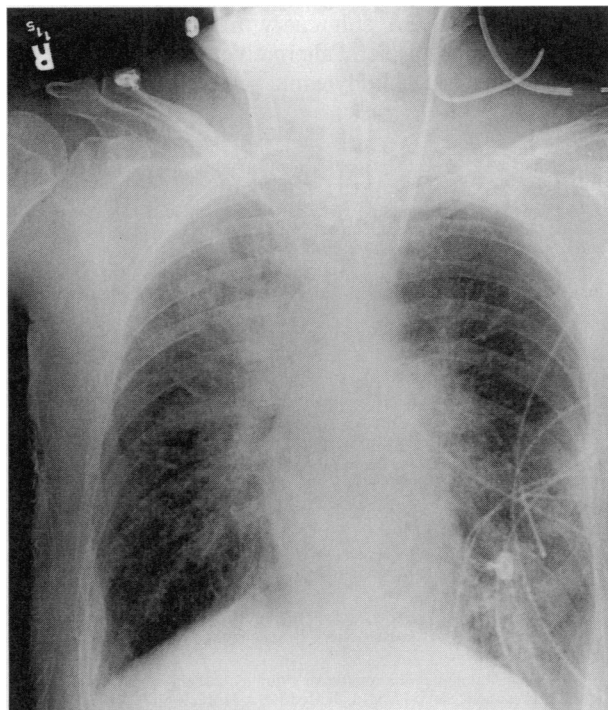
The chest radiograph shows Kerley's B lines and mediastinal widening.
